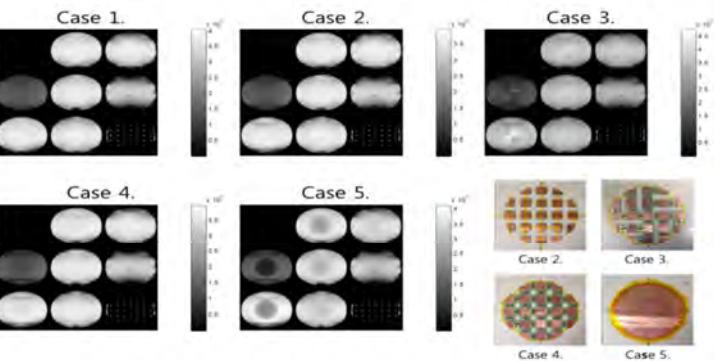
MR imaging results without electrode (Case 1), with copper pieces (Case 2), electrodes made of copper pieces with switching circuits A (Case3, electrode A) and B (Case 4, electrode B) and complete circular copper electrode (Case5). Case 4 with proper switching circuit (B) shows almost identical results as Case 1 or 2.
